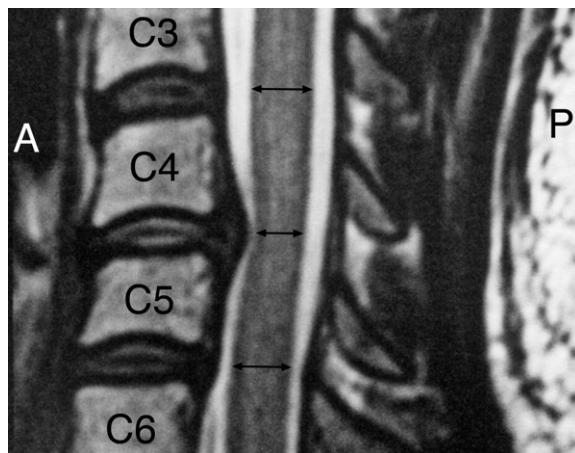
Cervical spine MRI sagittal T2-weighted image. Note that the posterior disc herniation at C4-5 compresses the anterior surface of the spinal cord where its diameter is measured at 4 mm (shorter arrow) on the MRI scan, whereas the diameter of the cord is 5 mm at the C3-4 and C5-6 levels (longer arrows).
